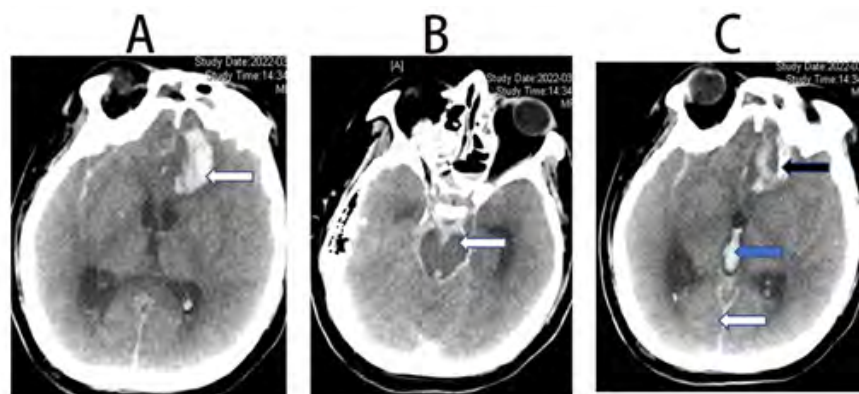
The plain computed tomography finding of brain on 8th day of admission to our department
